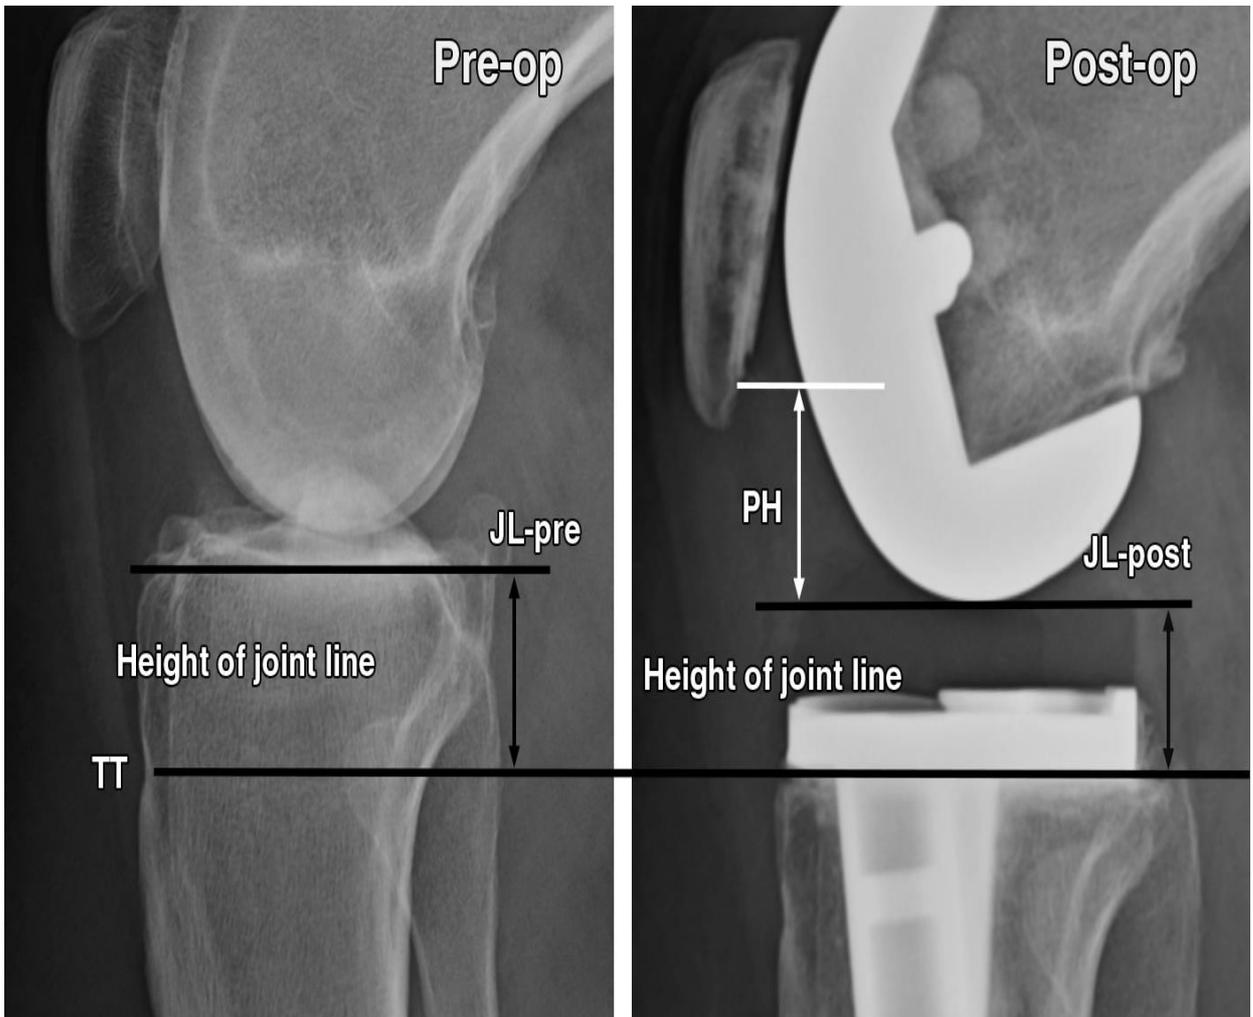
3 Radiographs showing knees before TKA (left) and after TKA (right).
